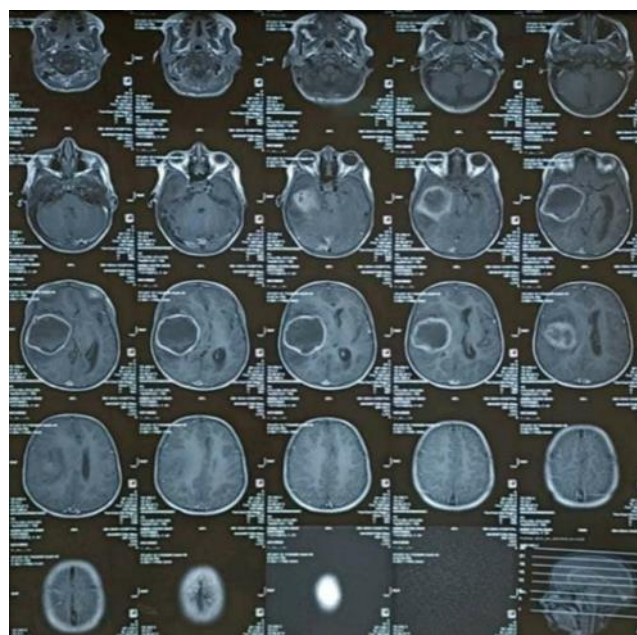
Brain CT with contrast well-defined right temporal ring-enhancing spaced occupied lesion.
